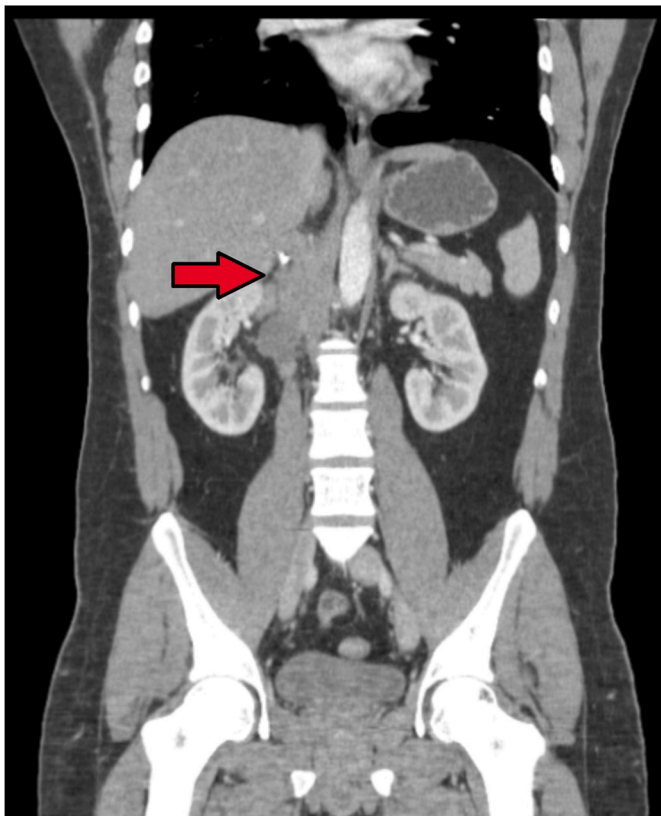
Abdominal contrasted computed tomography showing a tumor on the superior pole of the right kidney over the right adrenal gland.
